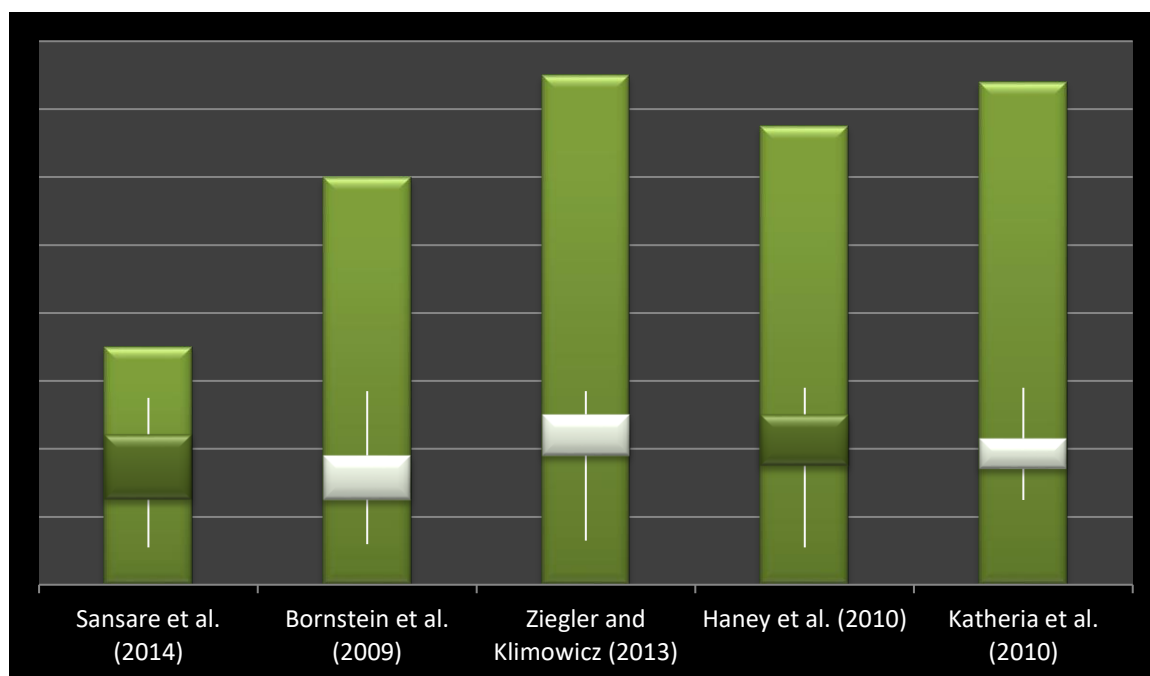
Box and whisker plot showing the analysis of different studies for diagnostic efficacy of CBCT in paediatric patients
